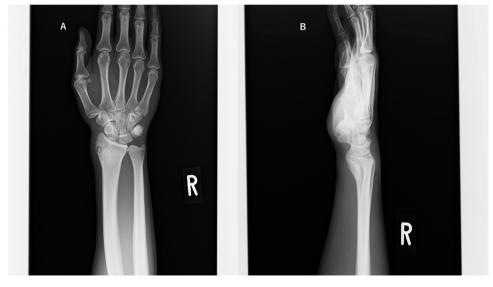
X-ray of the right wrist with a nidus and central mineralization at the second general hospital.
